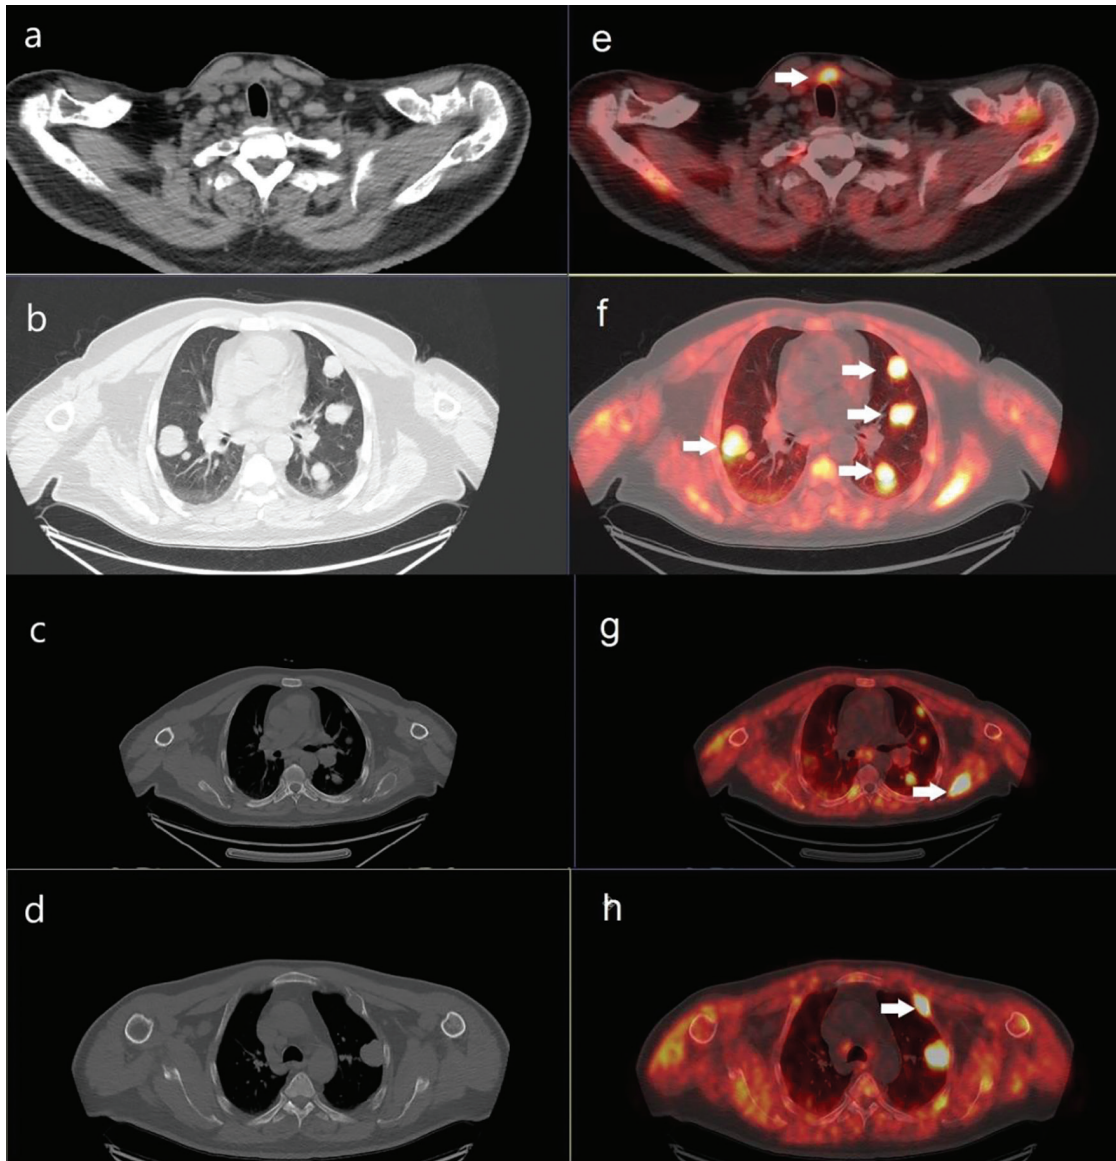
^{18}F Fluorine-fluorocholine positron emission tomography/computed tomography: the axial images depict an increased uptake of the radiopharmaceutical in the pretracheal nodular lesion (a,e), corresponding to a local relapse; pulmonary nodules (b,f), corresponding to metastasis of the parathyroid carcinoma; osteolytic lesions in the left scapula (c,g) and the second rib on the left (d,h), corresponding to metastatic disease
